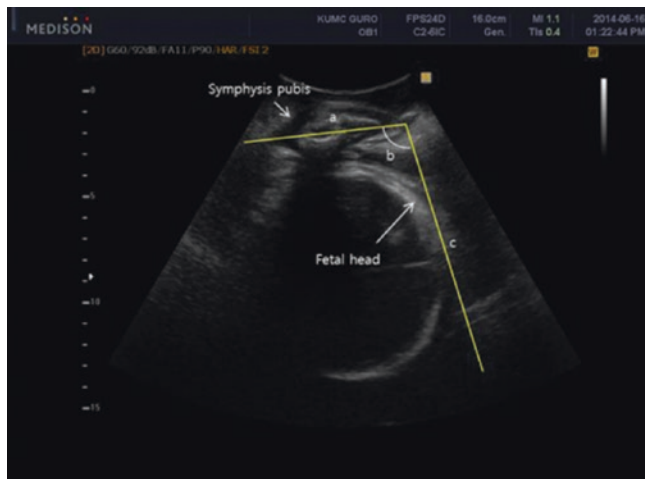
Angle of progression on transperineal ultrasound. Transperineal ultrasound image (sagittal view) depicting the long axis of the pubic symphysis (a), angle of progression (b), and line extending from the lowermost point of the symphysis tangentially to the fetal skull contour (By Ahn and Oh [78])
